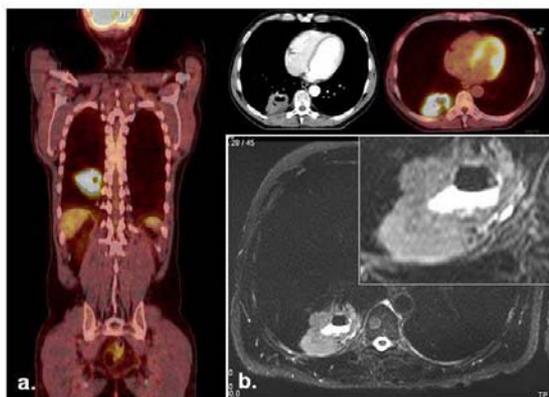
Patient with a tumor not suspected to infiltrate the chest wall according to PET-CT (a).
